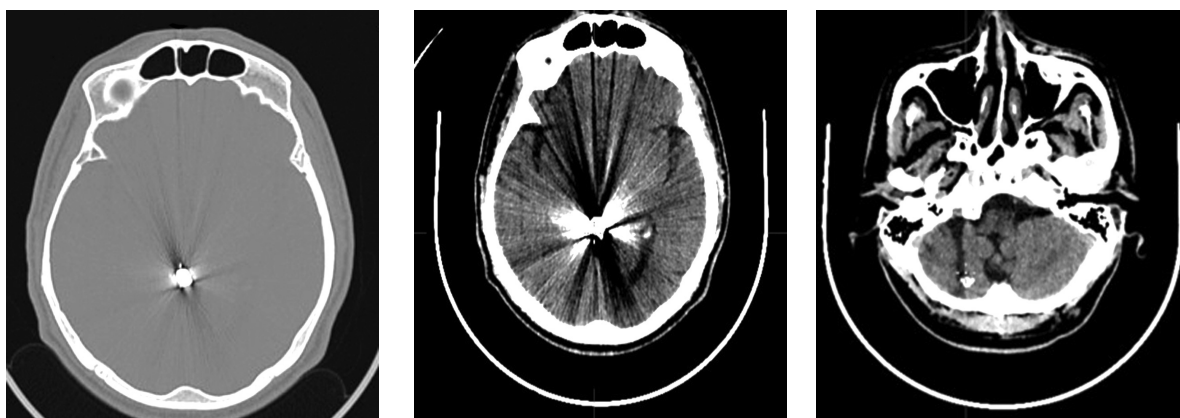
Patient D. Head CT — condition after resection-decompression trepanation of the parietal bone on the right; a massive area of cystic-atrophic changes is noted in the right occipital, both parietal lobes and the frontal lobe on the left with approximate dimensions of  $105 \times 20$  mm; in the cortical sections of the left frontal lobe, a foreign body of metallic density with dimensions of  $9 \times 8$  mm is noted
